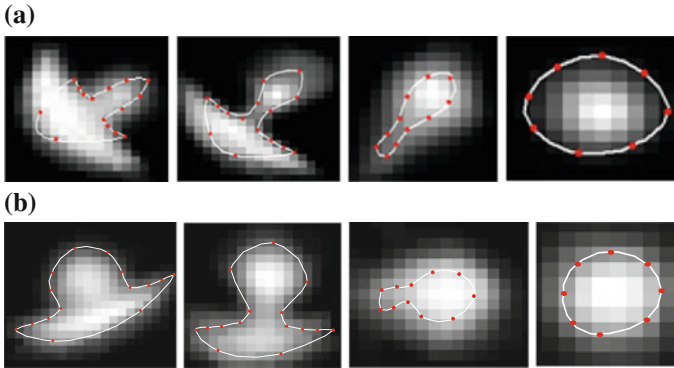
AAM Models for lung nodules from clinical CT scans. *Right-to-left*: juxta-pleural, pleural tail, vascular, a well-circumscribed nodule models. a Average nodules from ELCAP study. b Average nodules from LIDC study
